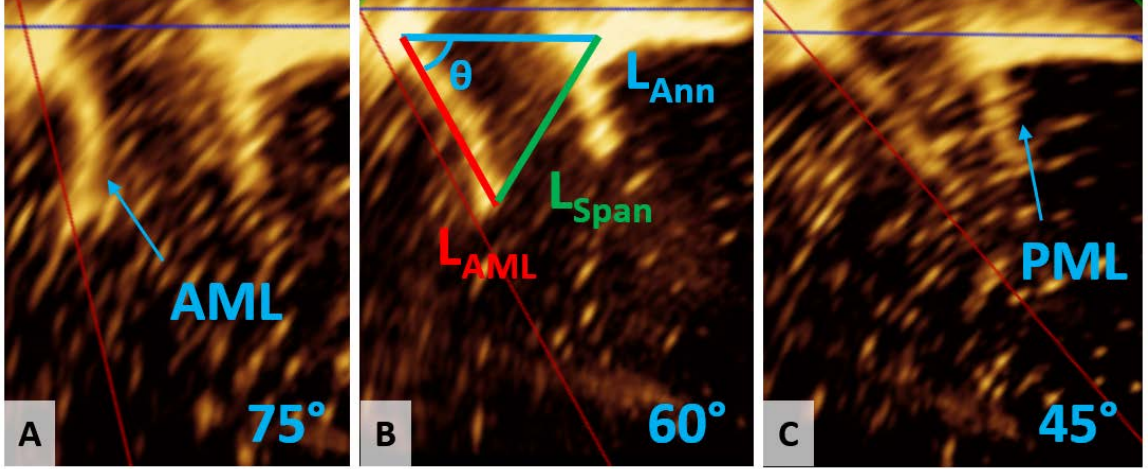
Measurement of AML tether angle using 3D echocardiography. For each anterior mitral leaflet (AML) tether angle, the distance from the annulus to the AML leaflet tip, L_{AML} , was measured, followed by the width of the annulus, L_{Ann} , and the span between the posterior annulus and the AML leaflet tip, L_{Span} . The angle of the AML with respect to the annular plane was then calculated using Equation 1. PML – Posterior mitral leaflet.
